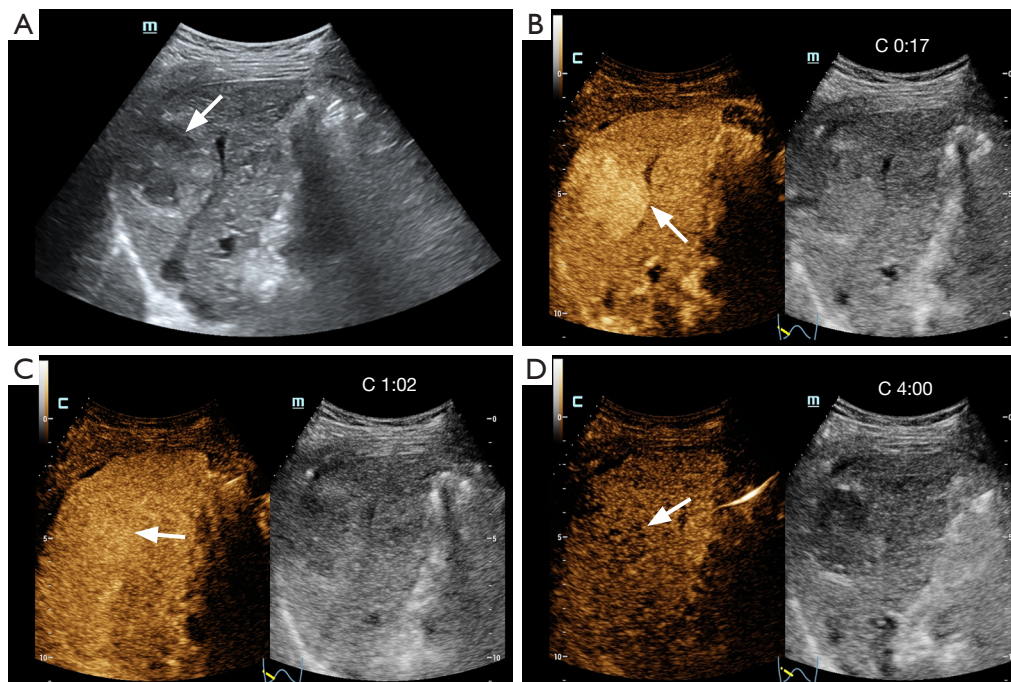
An LR-5 lesion in a 52-year-old male patient with CHB. (A) A heterogeneous hypoechoic lesion measuring 4.5 cm × 4.0 cm, with ill-defined margins and irregular shape, was detected in the upper segment of the right liver lobe on gray-scale ultrasound (arrow). (B) CEUS of the lesion during the arterial phase revealed homogeneous hyperenhancement (arrow). (C) In the portal phase, the lesion exhibited isoenhancement (arrow). (D) The lesion exhibited slightly reduced enhancement in the late phase (arrow). The lesion was classified as LR-5, and pathological examination confirmed that it predominantly consisted of HCC, which was poorly differentiated. Pathological analysis also confirmed the presence of cirrhosis (S4). C, contrast timer; CHB, chronic hepatitis B; CEUS, contrast-enhanced ultrasound; HCC, hepatocellular carcinoma; S4, Scheuer classification for cirrhosis, stage 4.
